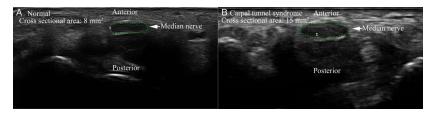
Neuromuscular Ultrasound of Median Nerve CSA
